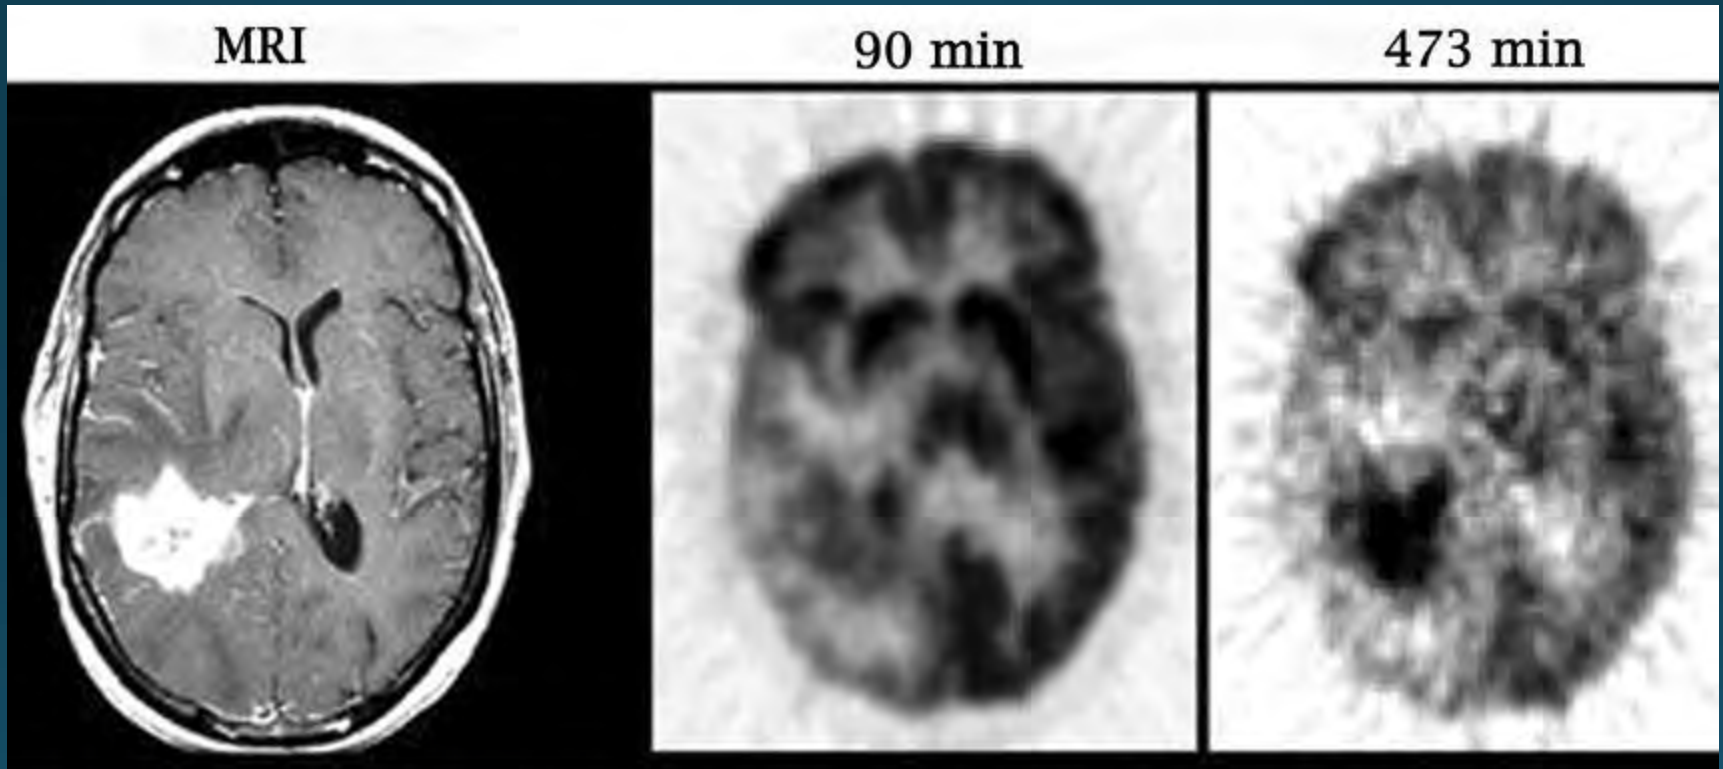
A 45-year-old woman with a recurrent right temporal glioblastoma. MRI shows contrast enhancement. Note the much more prominent tumor to gray matter delineation at the later time point, 473 minutes, compared with 90 minutes. (Reprinted by permission of the Society of Nuclear Medicine from Spence et al.¹⁴)
